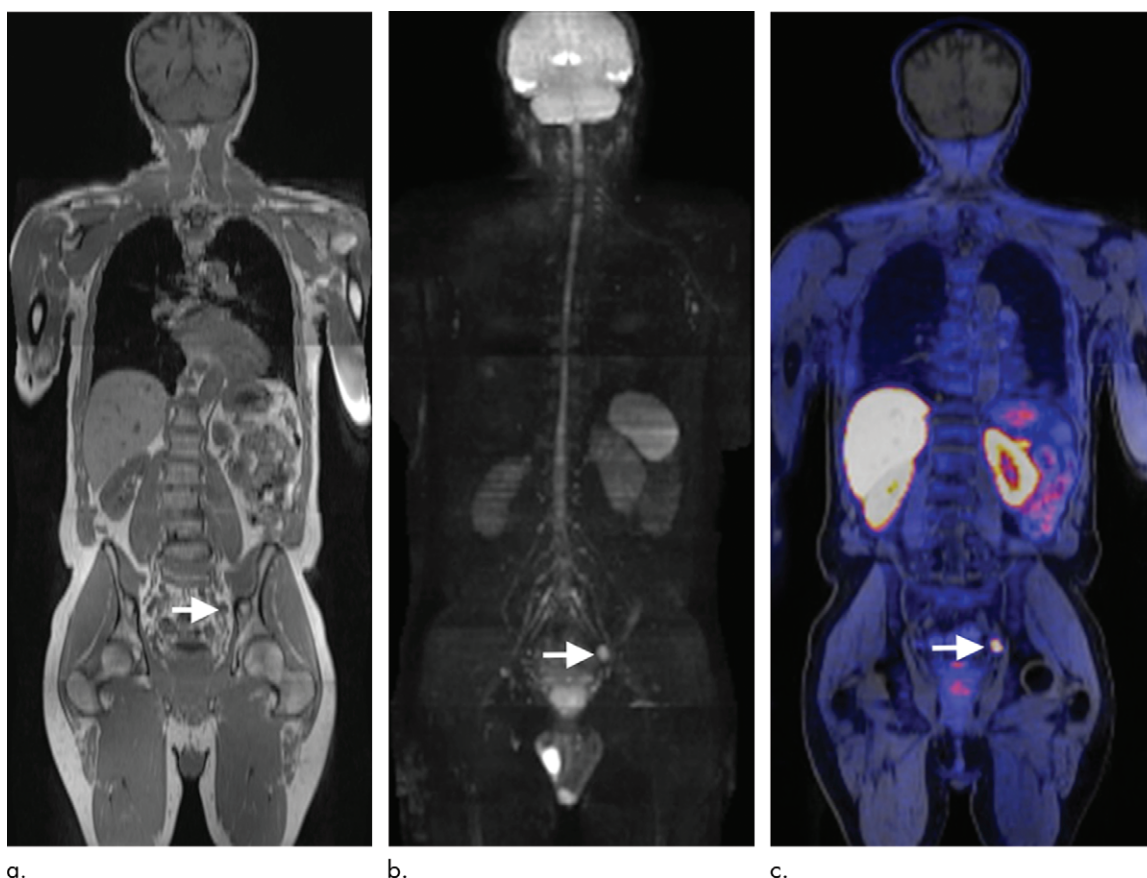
A 63-year-old man with high-risk Gleason 4+3 prostate cancer underwent fluorine 18 (^{18}F) choline PET/MRI to detect malignant nodal disease. (a) Coronal T1-weighted PET/MRI shows a 1-cm node (arrow) in the left pelvic sidewall. (b) Coronal diffusion-weighted MRI (b value = 900 sec/mm²) shows impeded diffusion (arrow). (c) Coronal fusion ^{18}F choline and T1-weighted MRI shows increased tracer activity within the node (arrow), suggesting disease involvement. (Images courtesy of Dr Gary Cook.)
